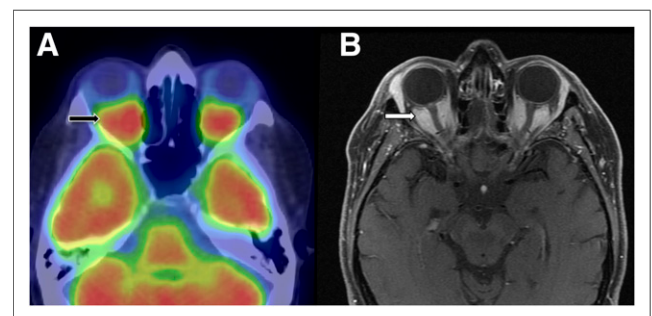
59-y-old man with orbital pain. (A) Axial fused ^{18}F -FDG PET/CT demonstrates ^{18}F -FDG-avid soft tissue encasing intraconal spaces (arrow). (B) Corresponding axial T1-weighted fat-saturated contrast-enhanced MRI depicts enhancing intraconal soft tissue (arrow).
